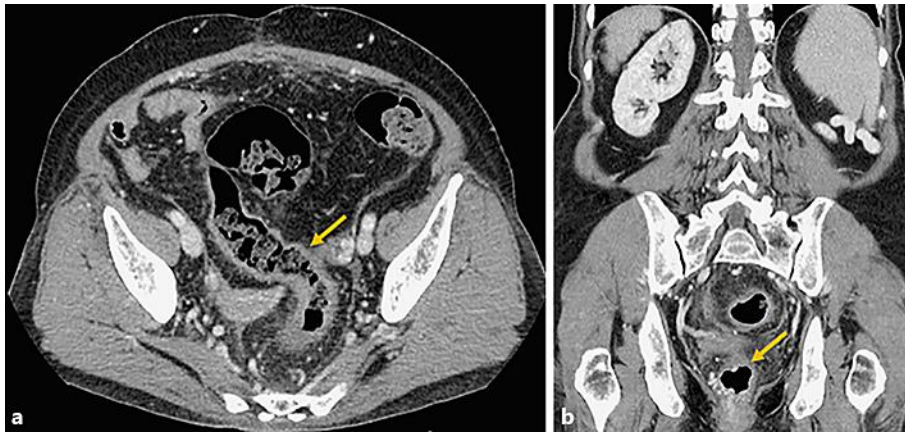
Computed tomography of the abdomen, axial view (a) and coronal view (b), after 3 weeks of antibiotics treatment showing marked improvement of phlegmonous proctitis.
